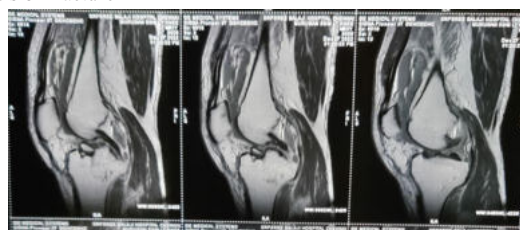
Sagittal view of MRI Left knee shows complete ACL tear
